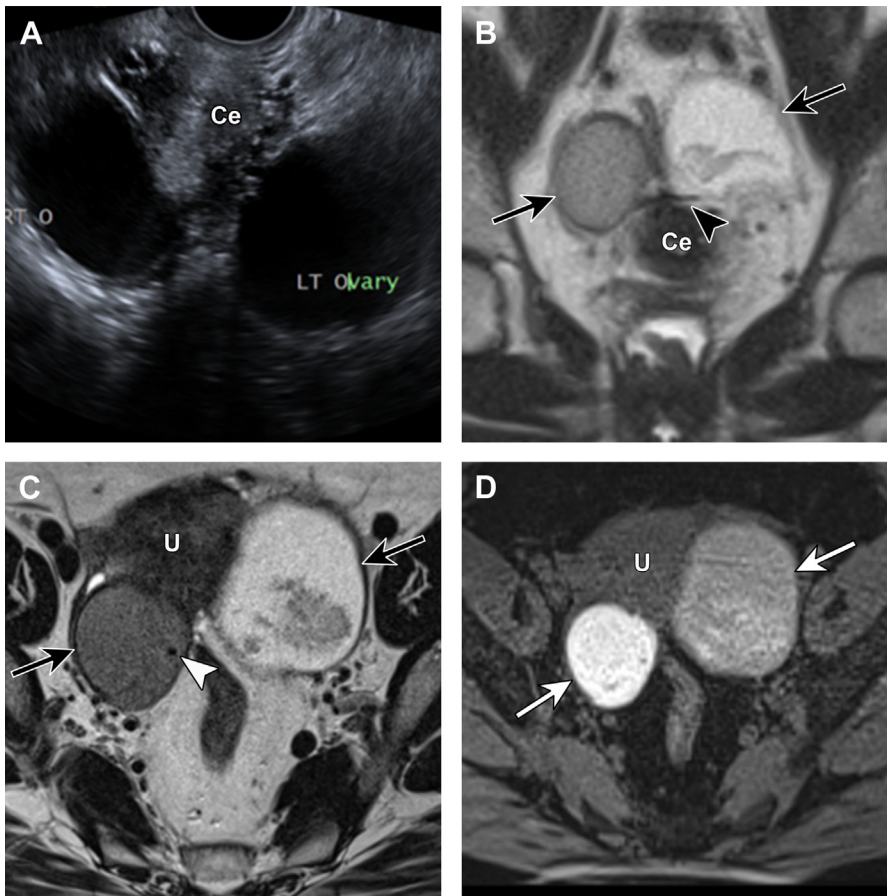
Kissing ovaries/endometriomas indicating concomitant deep infiltrating endometriosis. Transvaginal pelvic ultrasound (A) shows bilateral cystic lesions oriented adjacent and posterior to the cervix (Ce). Coronal T2-weighted MR image (B) and axial T2-weighted MR image (C) show bilateral kissing ovaries (black arrows) posterior to the cervix (Ce) and uterus (U) with abutment of bilateral cystic lesions. There is a thin fibrotic band of adhesion between the ovaries and cervix (black arrowhead) and further adhesion along the uterus. There is T2 shading in both lesions and a T2 dark spot on the right (white arrowhead). Axial T1-weighted MR image (D) without contrast and with fat saturation shows typical T1-weighted hyperintensity of an endometrioma on the right and heterogeneity of the lesion on the left (white arrows). Given the pattern of disease, the left sided lesion is likely also an endometrioma, although a hemorrhagic cyst could also have this appearance.
